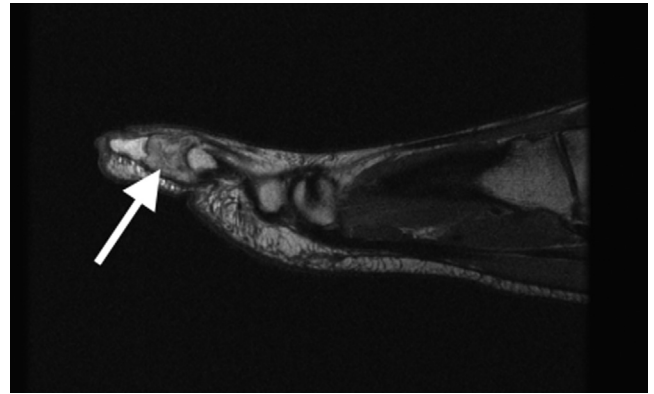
Pro-time density magnetic resonance image showing an expansile hyperintense mass that has replaced much of the third middle phalanx (arrow).
